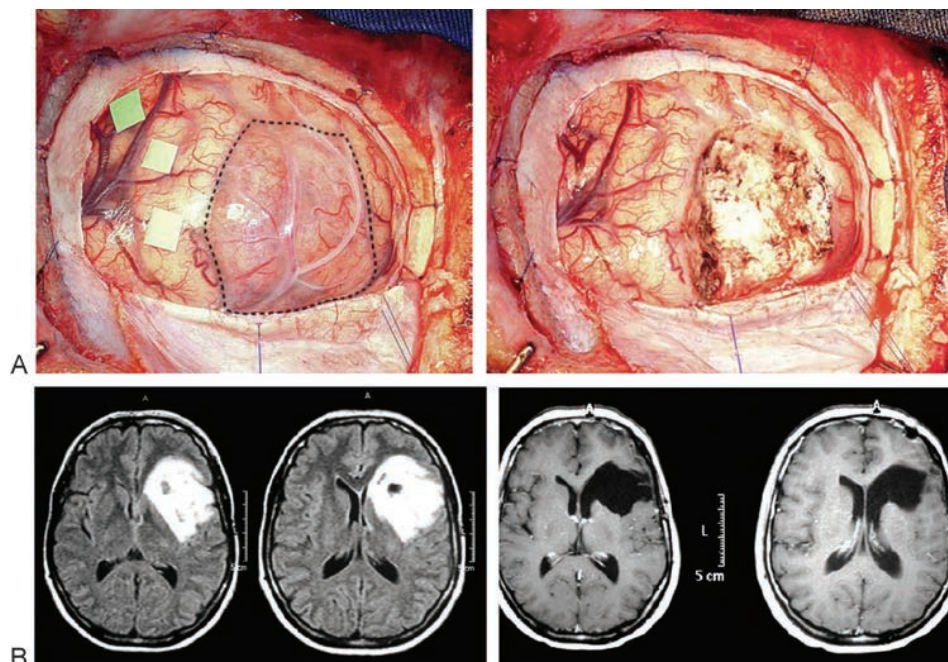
(a) Surgery of a 50-year-old patient harboring a high-grade glioma in the posterior region of the central lobe. The anatomical localization of the pre-central gyrus (dotted area) was achieved without the use of auxiliary methods, and the patient recovered with normal muscular strength. (b) Pre- and postoperative axial MRI of a 34-year-old patient harboring a left fronto-insular glioma. The surgery was performed with local anesthesia and the patient recovered without motor or speech deficits.
